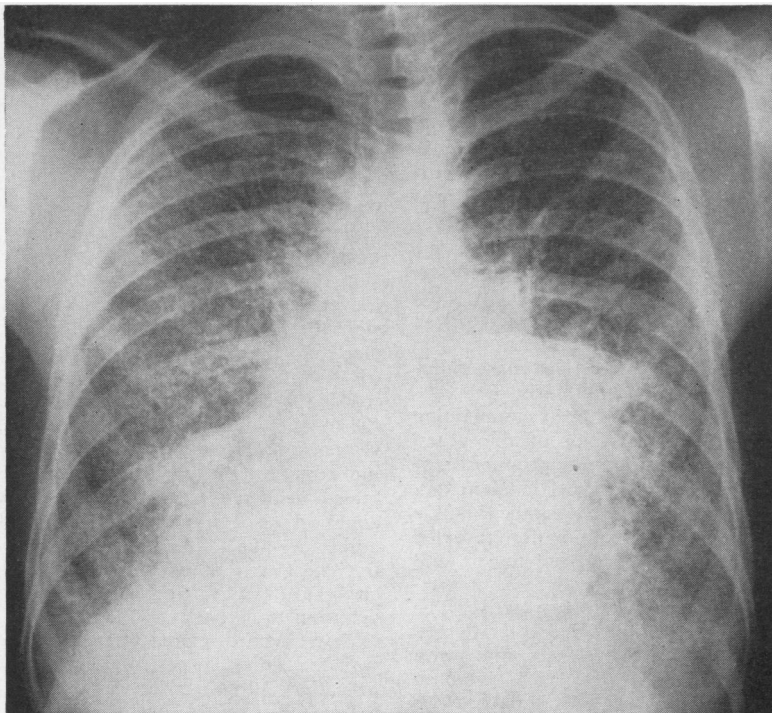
Typical radiograph (case 2) showing fine granular calcific densities throughout both lungs.
